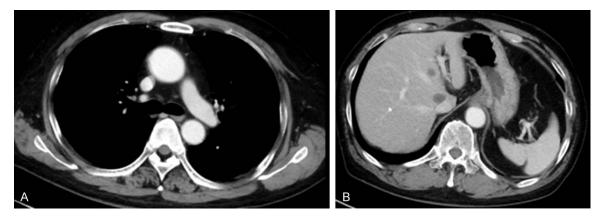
Whole-body CT. A. Chest: no abnormalities; B. Abdomen: no abnormalities.
